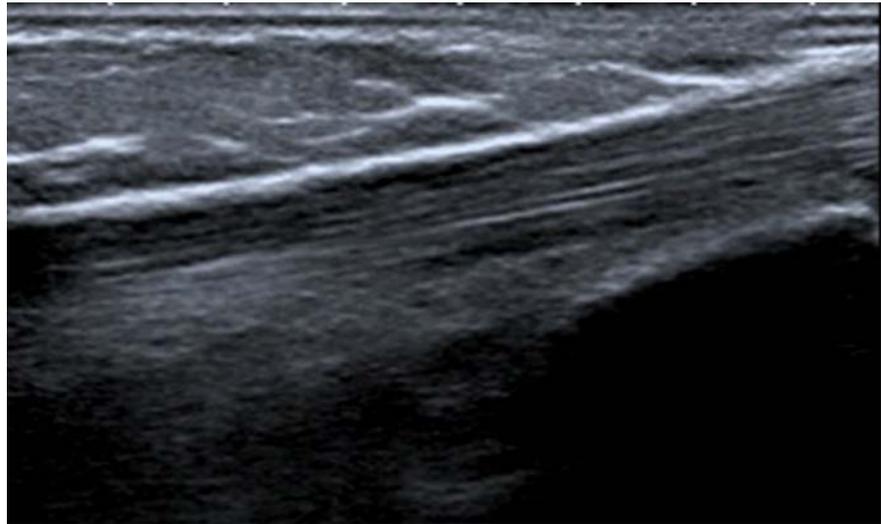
Ultrasound image demonstrates the normal appearance of left tibialis posterior tendon.
